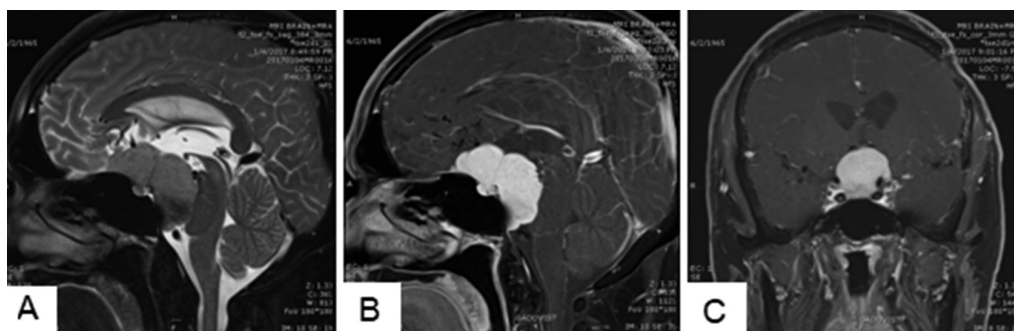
Sagittal fat suppression T2-weighted image (A) and sagittal (B), coronal (C) Gd-enhanced fat suppression T1-weighted image demonstrated a meningeal-based mass at planum sphenoidale, suprasellar region and retroclivus which appeared isointensity on T2Wi with homogeneous enhancement.
